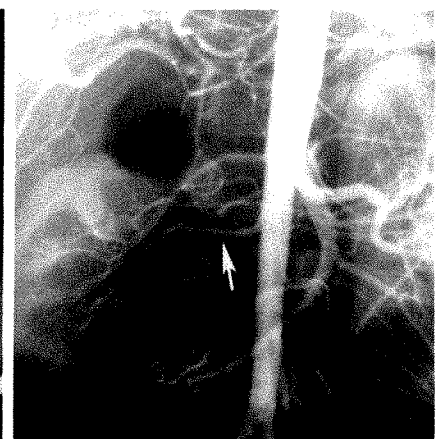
5-year-old boy crushed by dumpster. CT scan shows vascular compromise of most of right lobe of liver and right kidney. Note sharp cutoff of right portal vein (arrow) and flattening of inferior vena cava. Fever, abdominal pain, and leukocytosis developed 1 week later; a partial hepatectomy was required because of infection in infarcted portions of liver.
